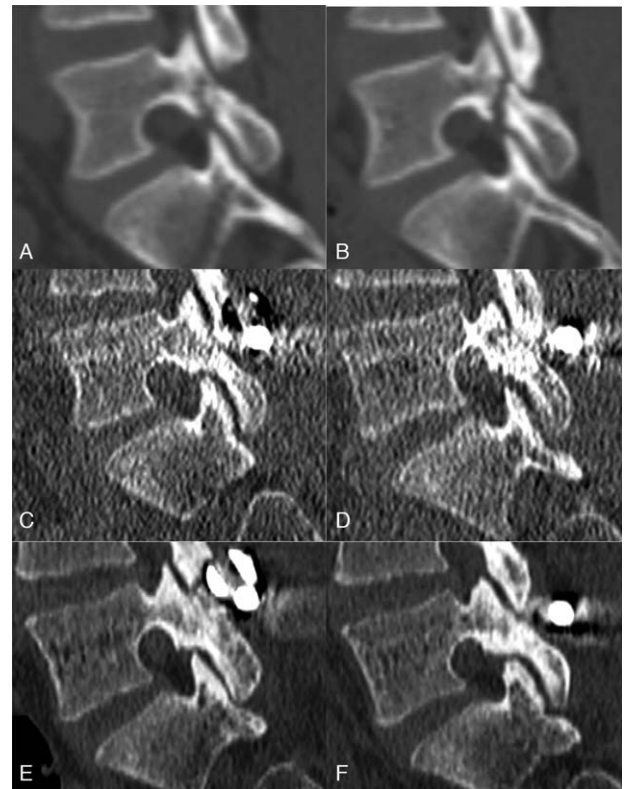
Case example. Screw-Rod-Band (SRB) Technique. Preoperative CT scan, (A) left and (B) right side. Low dose CT scan at 4-month follow-up, (C) left, and (D) right side. CT scan at 4 years follow-up, (E) left and (F) right side.
